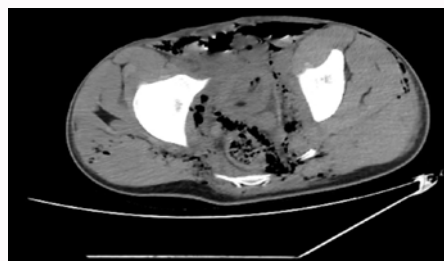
Axial Pelvic non contrast CT scan showing pelvic subcutaneous emphysema with extra-peritoneal rectal wall disruption.
